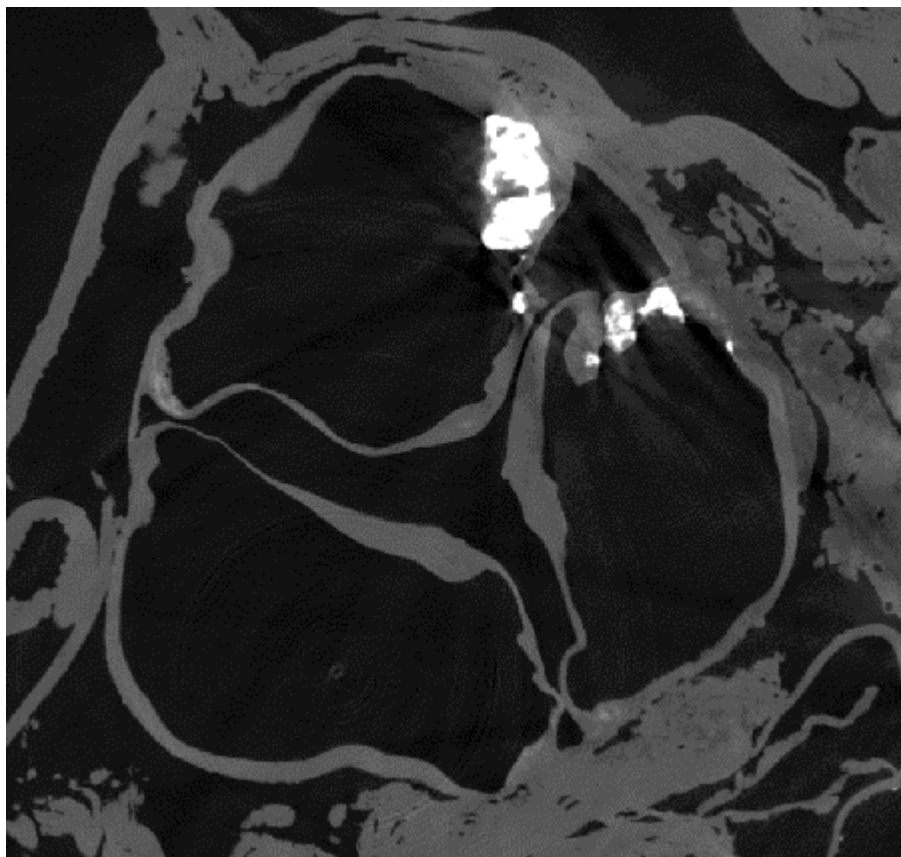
μ CT slice of a human heart. The aortic valve and the three leaflets can be clearly seen approaching each other in the centre of the image. Calcified plaques are present in the image, highlighted in bright white.
